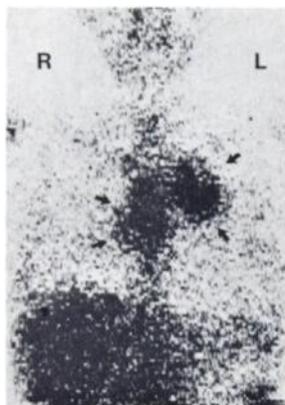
Case 1. 24-hr Ga-67 scan showing intense uptake in bilateral hilar masses. (arrows). Right hilar lesion was not suspected on chest radiograph.
